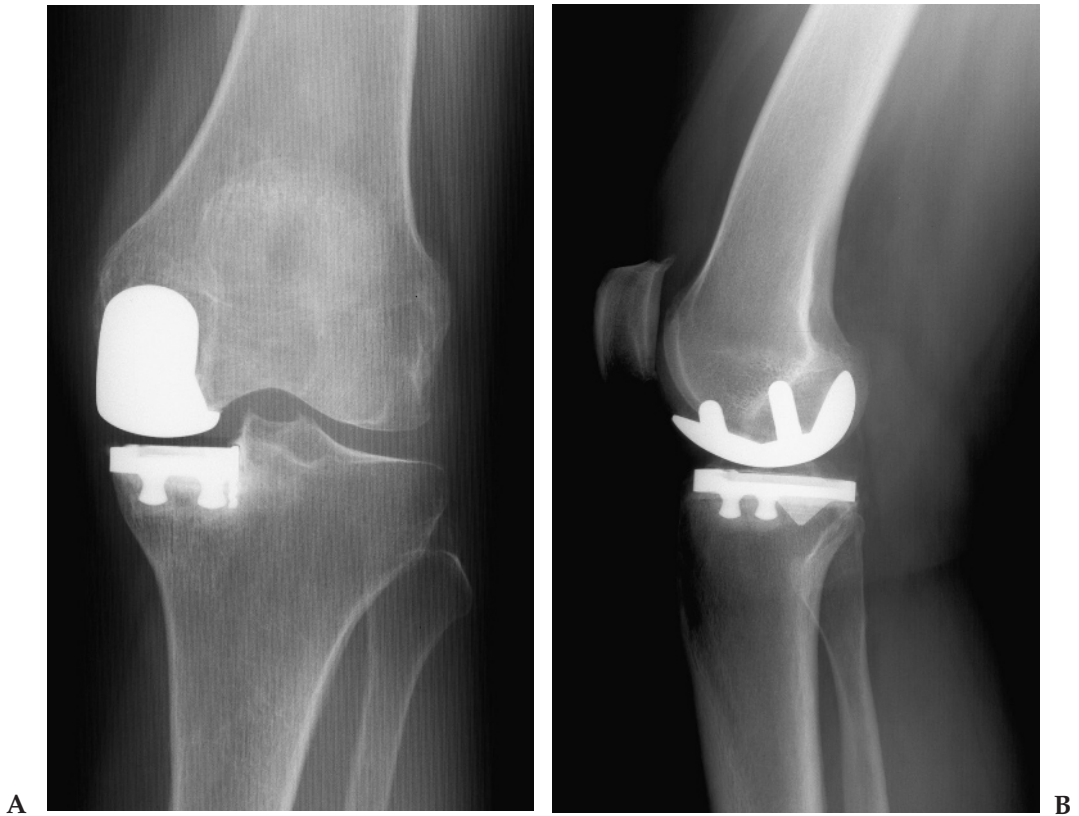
(A) Postoperative AP and (B) lateral x-ray of an MG unicompartmental knee.
